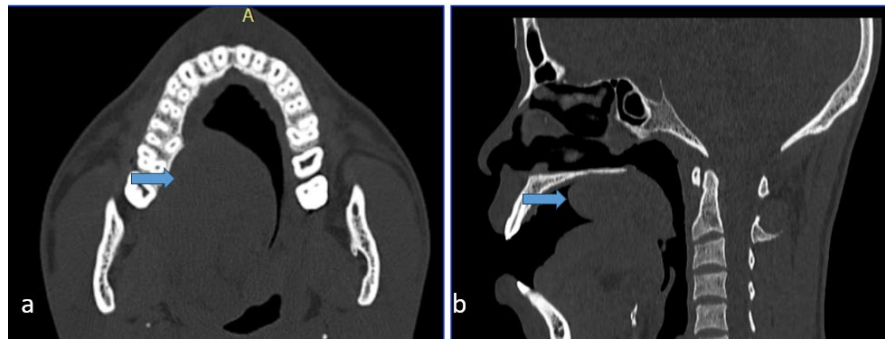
Facial computed tomography. (a) axial section showing a right palatal tumor without bone erosion (blue arrow); (b) sagittal section showing the palatal lesion (blue arrow).
